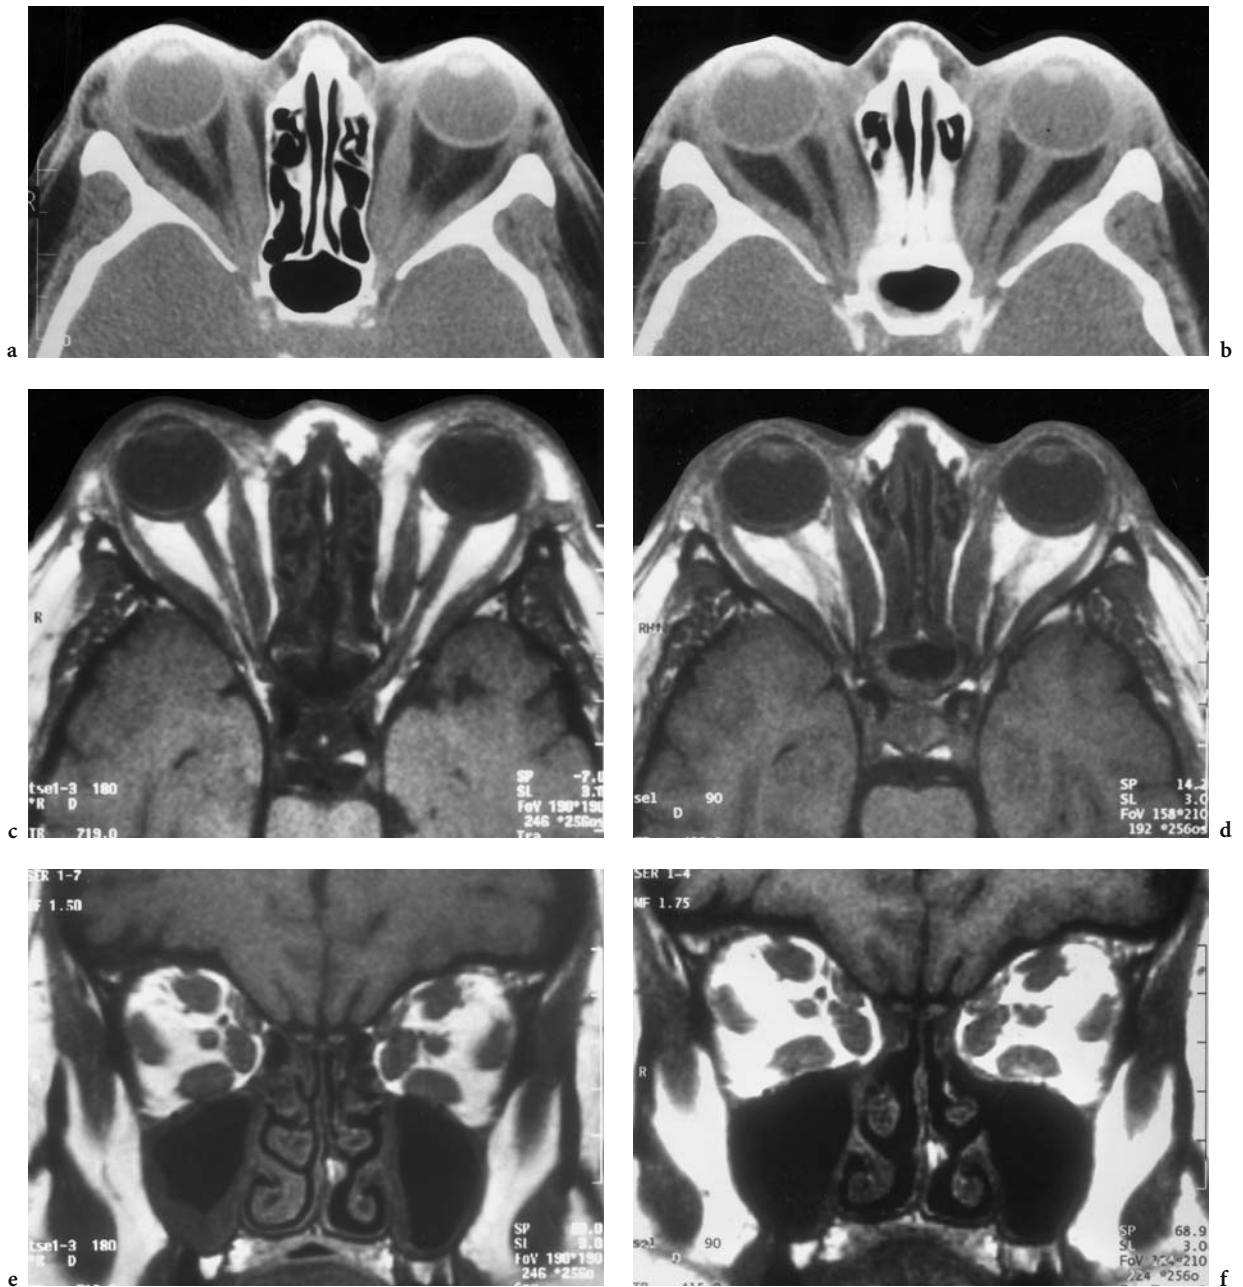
A 50-year-old woman with bilateral proptosis in the course of Graves' disease. Diagnosis: Graves' disease. CT: a Preoperative view with bilateral symmetric enlargement of the medial and (less marked) lateral rectus muscles. Note slight impression of the medial orbital wall as some spontaneous decompression. b Corresponding postoperative view with protrusion of the medial rectus muscles in the former ethmoidal cell area. MRI: c axial T1-weighted view, corresponding to a. d Corresponding postoperative image. Note that the enlargement of the muscles themselves remains unaffected. e Coronal T1-weighted preoperative view. f Corresponding postoperative image
